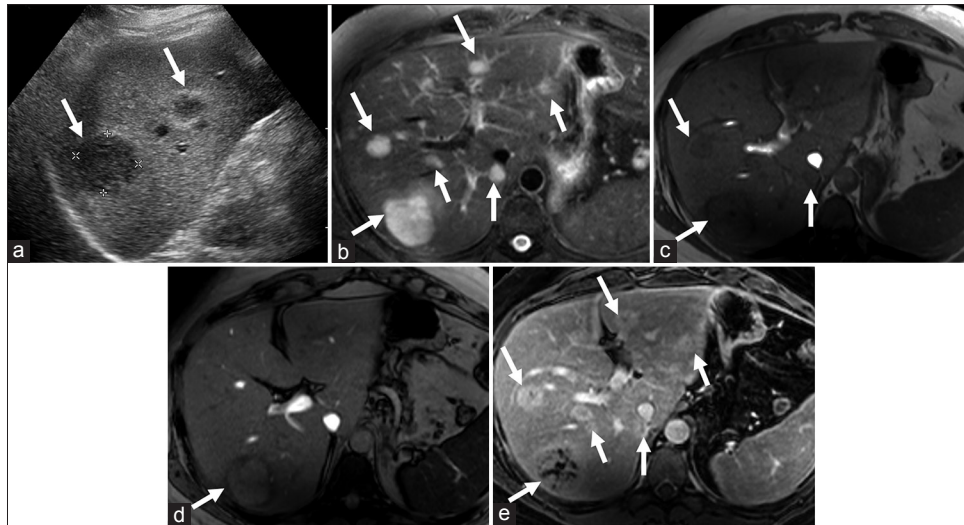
28-year-old man with HIV associated hepatic tuberculosis. (a) Transverse ultrasound image of the liver demonstrates well-defined hypoechoic lesions (arrows) in the right lobe. (b) Axial T2W MR image of the liver reveals high-signal intensity of the lesions (arrows). (c, d) Axial dual-echo in- and out-of-phase T1-weighted (T1W) MR images reveal the lesions (arrows) to be iso- to hypointense with peripheral hypointense rim. Note that the larger lesion has greater signal loss on the longer TE (in-phase) sequence which is most likely explained by the caseous necrosis. (e) Axial T1W fat suppressed postgadolinium MR image in the venous phase demonstrates heterogeneous enhancement of the lesions (arrows). Ultrasound-guided biopsy of the lesions revealed granulomatous inflammation with acid-fast bacilli consistent with tuberculosis.
